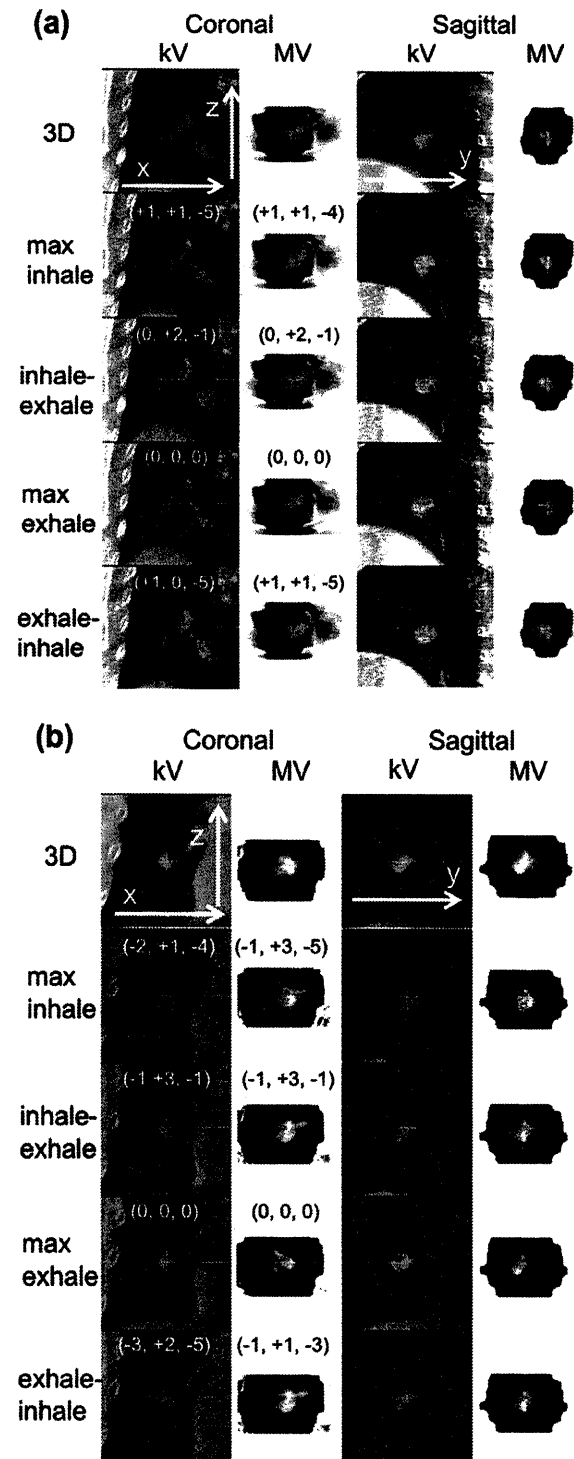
Coronal and sagittal images at the isocentre plane of in-treatment kV 3D- and 4D-CBCT and 3D- and 4D-VMAT CT for (a) patient 1 and (b) patient 2. The coordinates inside the images represent the COM of tumour shift from max exhale with units in mm for each modality. The COMs were estimated from a contour delineated in respective max-exhale volume images on the Pinnacle treatment planning system and by shifting the contour in the other images.
